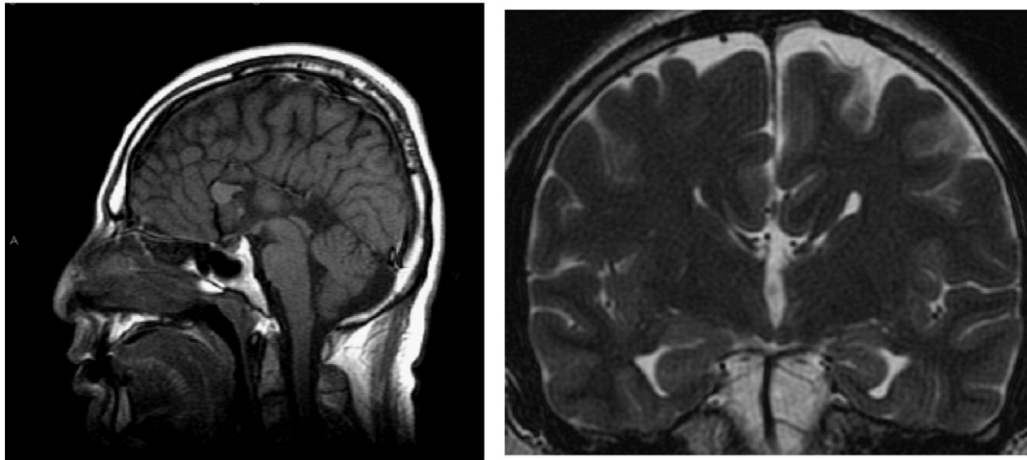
Structural MRI with images revealing partial agenesis of the corpus callosum with missing body and splenium. Part of the genu of the corpus callosum is seen.
